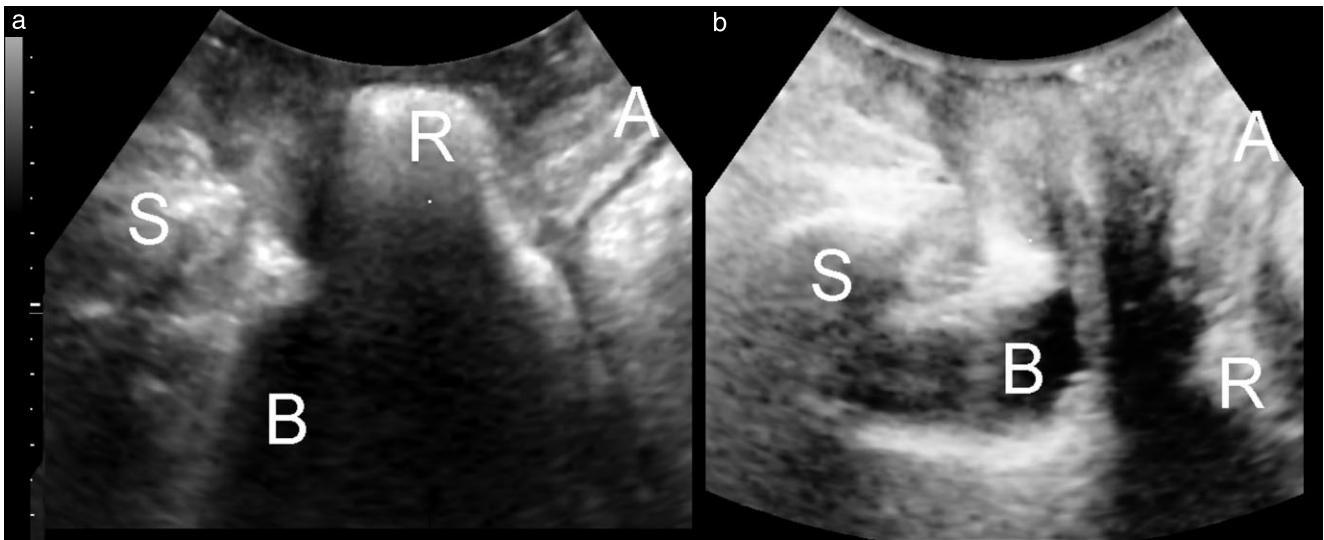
Sonographic appearance on Valsalva, before (a) and 6 months after (b) defect-specific rectocele repair. A, anal canal; B, bladder; R, rectocele/rectal ampulla; S, symphysis pubis.
